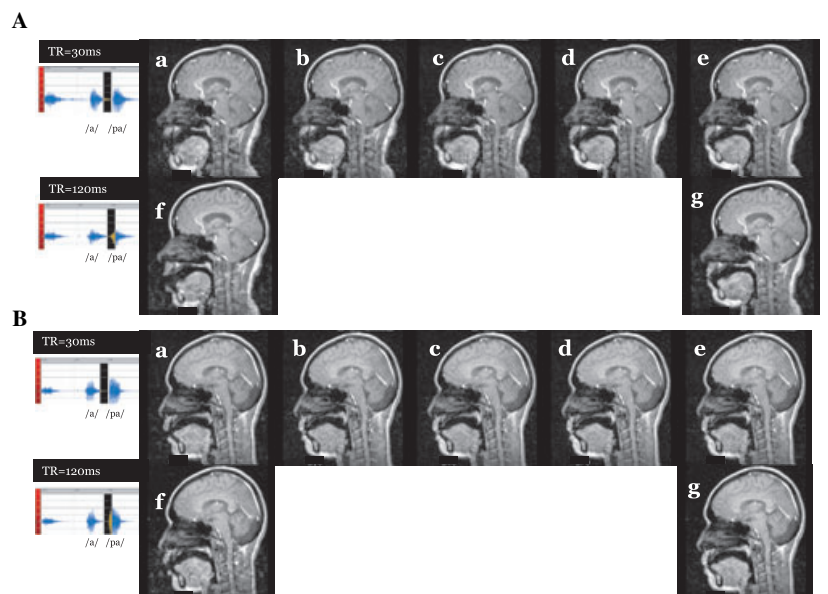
Images of MRI movie immediately before velopharyngeal closure from two representative subjects (A and B) with different time resolutions, i.e. 30 ms (a–e) and 120 ms (f and g). All images correspond to the timing in the voice records shown on the left; (e) denotes the timing of velopharyngeal closure ($t = 0$) when the time resolution was 30 ms, and (d), (c), (b) and (a) denote -30 , -60 , -90 and -120 ms, respectively, from $t = 0$. Also, (g) denotes the timing of velopharyngeal closure ($t = 0$) when the time resolution was 120 ms, and (f) denotes -120 ms from $t = 0$.
